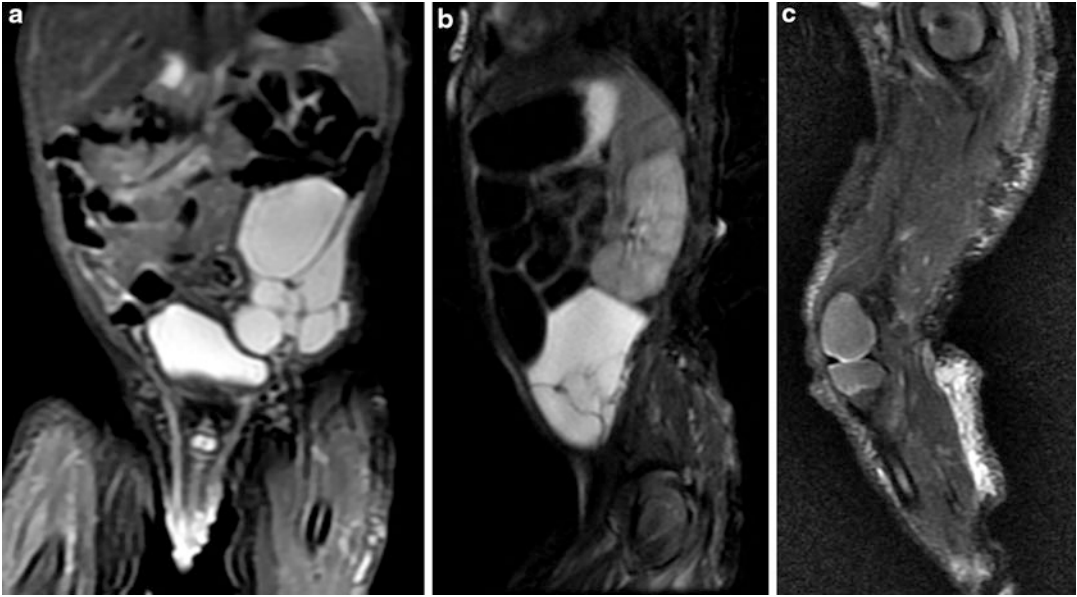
(a–c) This one-week-old boy was seen because of superficial venous capillary malformations of the left lower extremity. Prenatal ultrasound showed maternal hydramnios and an abdominal cyst. On examination, the diameter of the left lower extremity was larger than the right lower extremity. There was an extensive vascular malformation of the left lower extremity extending onto the lower portion of the trunk, gluteal region, and thigh. The majority of visible portion appeared to be capillary malformation with the purple color. The clinical diagnosis of Klippel-Trenaunay-Weber syndrome with intra-abdominal lymphatic malformation and superficial venous capillary malformations of the left lower extremity was
